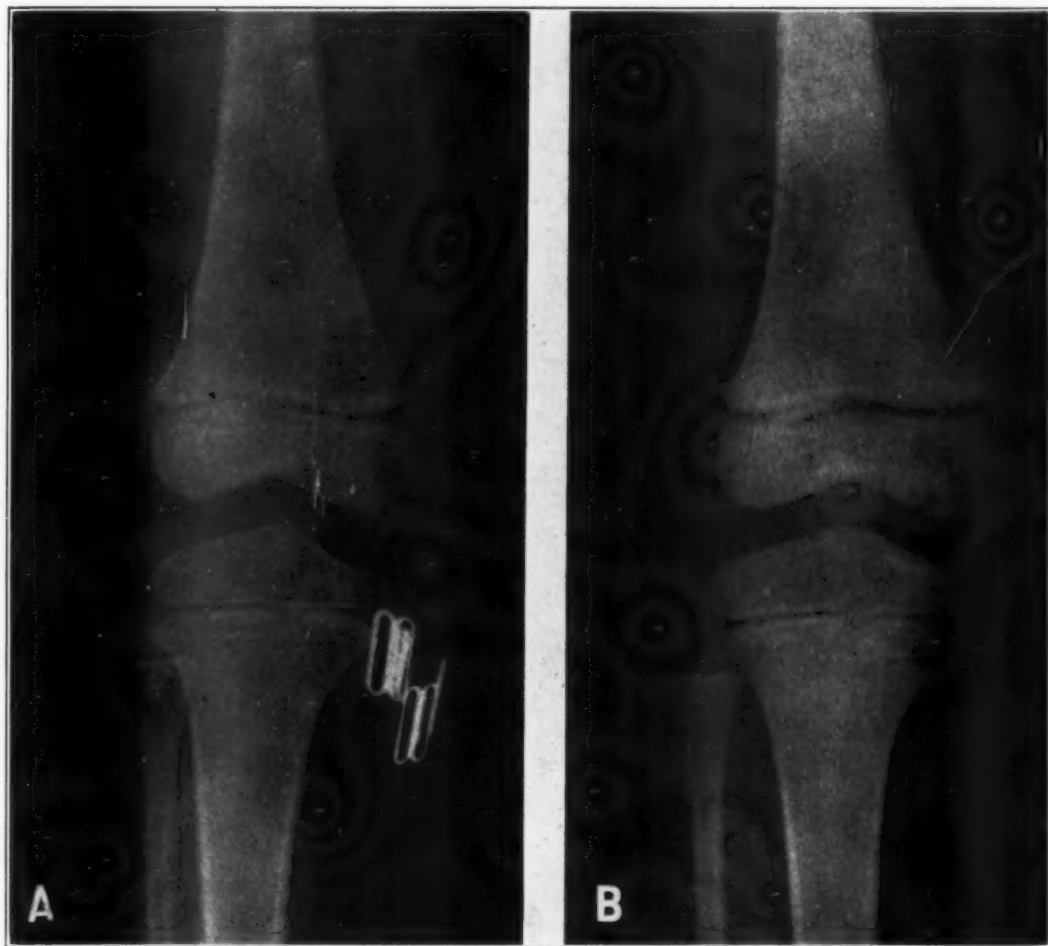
Roentgenograms of left knee, SS 928, male, white, age *A* 5 years; *B* 6 years. Note in *A* the scar recording a tenotomy performed 6 months previously. This scar is present a year later in *B* though fainter, thinner, and now interrupted in continuity. A new scar appears between the old one and the articular surface of tibia. This was produced by an attack of measles 9 months before roentgenogram *B* was made.
